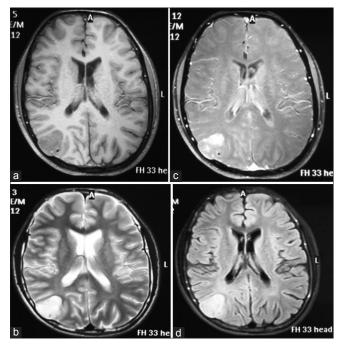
Magnetic resonance imaging brain showing axial image of hypointense mass on T1-weighted image (a), hyperintense mass on T2-weighted image (b), which is heterogeneously contrast enhancing (c), and hyperintense on fluid-attenuated inversion recovery sequence (d)
